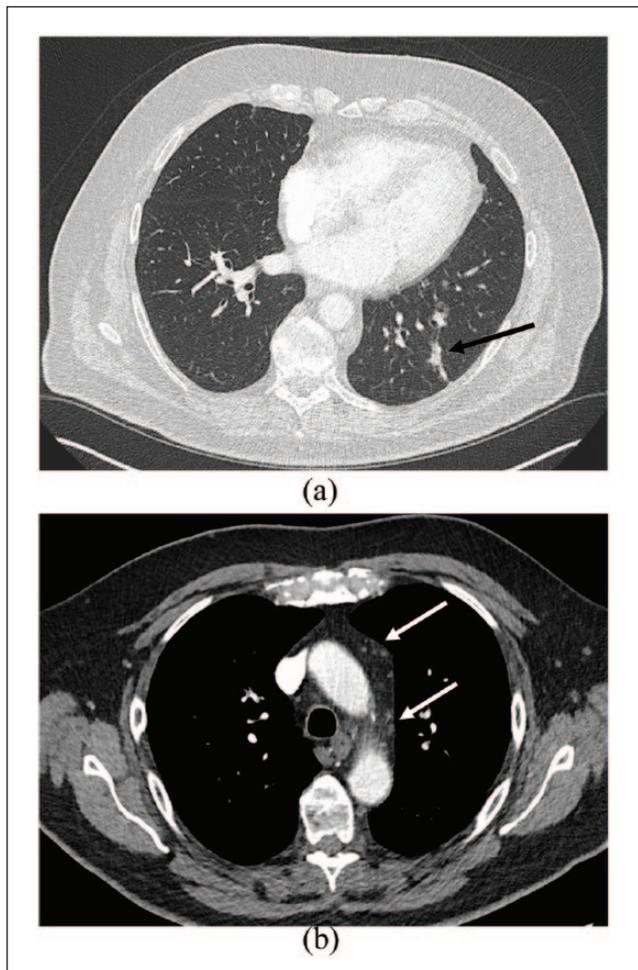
CT Scan image following the patient taking CBD: (a) marked regression of the left lower lobe mass leaving a small irregular residual linear band, and (b) striking regression of the mediastinal lymph nodes.
